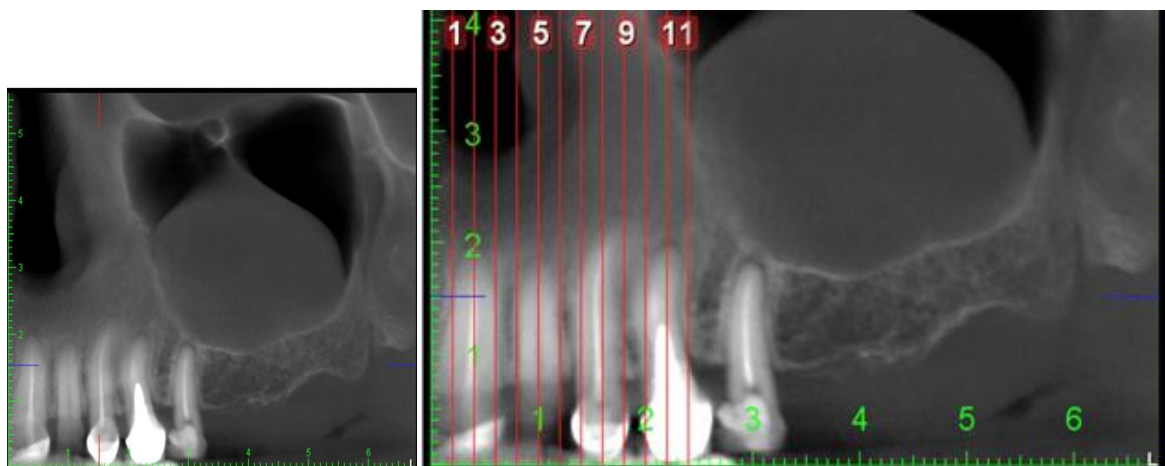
CBCT scan exams shows the presence of a neof ormation in the left maxillary sinus.
